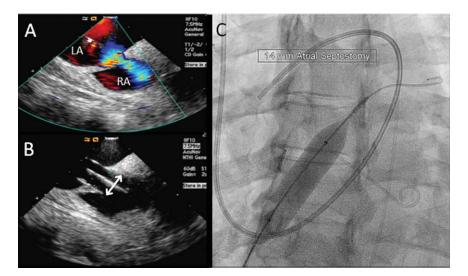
ICE and fluoroscopy of BDAS. A: Doppler image with right to left flow across the interatrial septum after successful balloon atrial septostomy. The right atrium is at the top of the image, the left atrium at the bottom. B: Balloon dilation of the interatrial septum over a guidewire. Arrow indicates diameter
